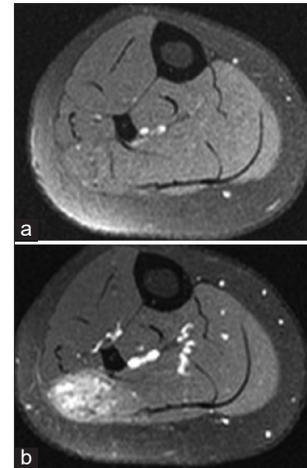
Pre (a) and post (b) contrast axial T1 fat-saturated axial Magnetic resonance images. This demonstrates the lateral soleus intramuscular arteriovenous malformations with intense enhancement after the administration of IV gadolinium.
